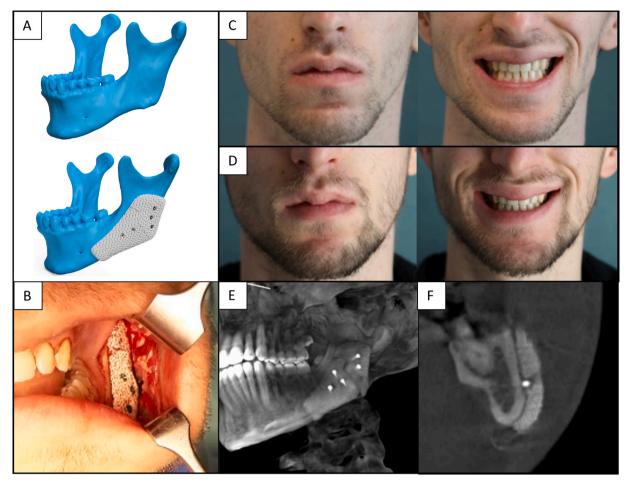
Mandibular augmentation — case 7: (A) 3D reconstruction of the defect and the planned HA-PSI; (B) intraoperative view of the MBCI; (C) preoperative photographs of the patient; (D) 1-month postoperative photographs of the patient; (E &F) postoperative cone-beam CT with sagittal and coronal views, respectively, showing the MBCI in place.
